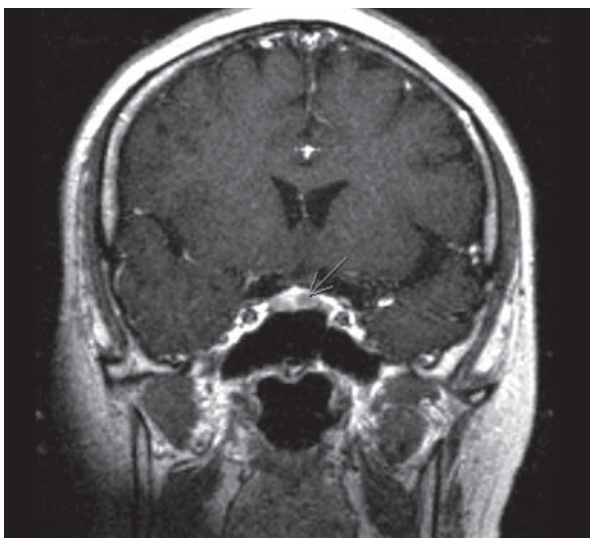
Pituitary MRI revealed microadenoma (7 x 5 x 5 mm) in the left-sided pituitary gland.
